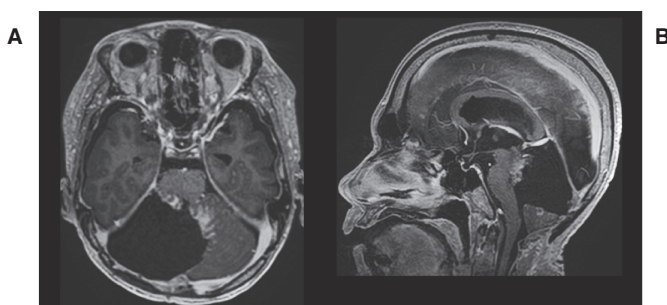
Contrast-enhanced T1-weighted image obtained after second surgery at our hospital. Axial (A) and sagittal (B) images. After surgery, cyber knife therapy was performed on the residual lesion.
